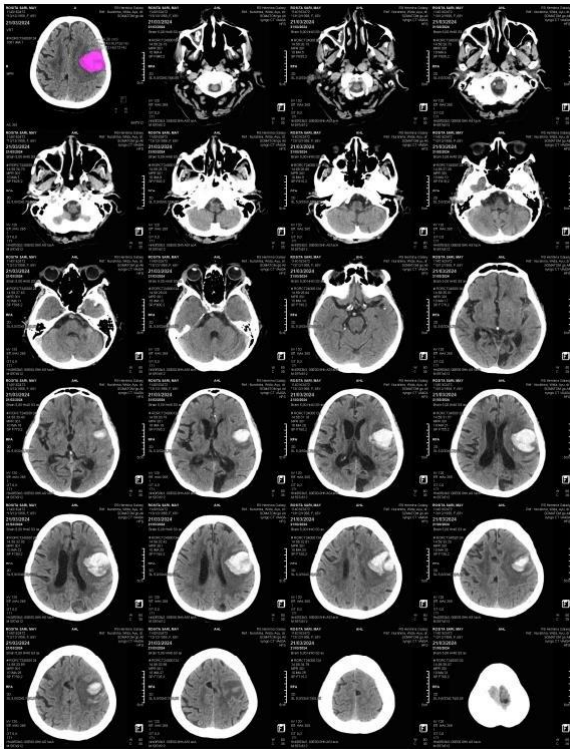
CT scan without contrast show hyperdense lesion in the left temporalis, bleeding volume \pm 34.28 cc, surrounded by cerebral edema, and the sacral cortex looks widened; the gyri are prominent; the ventricular system also looks widened; there is no midline shift; cerebral atrophy with hydrocephalus communicans; and infarction long in the left occipital lobe.
